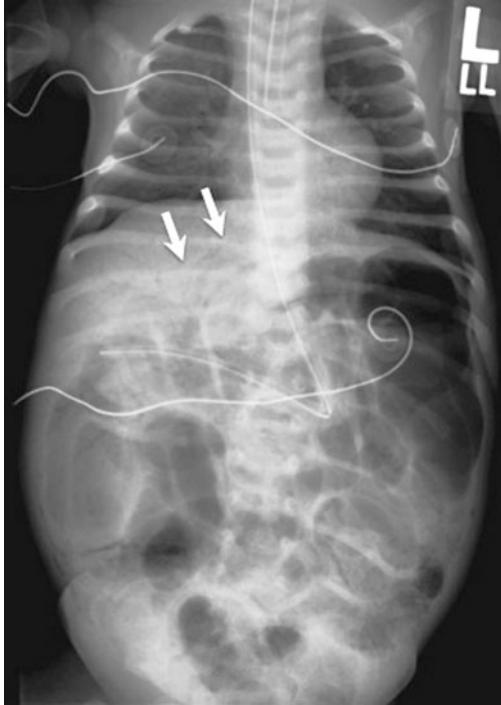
Abdominal x-ray of an infant with necrotizing enterocolitis demonstrating portal venous gas, indicated by arrows.
